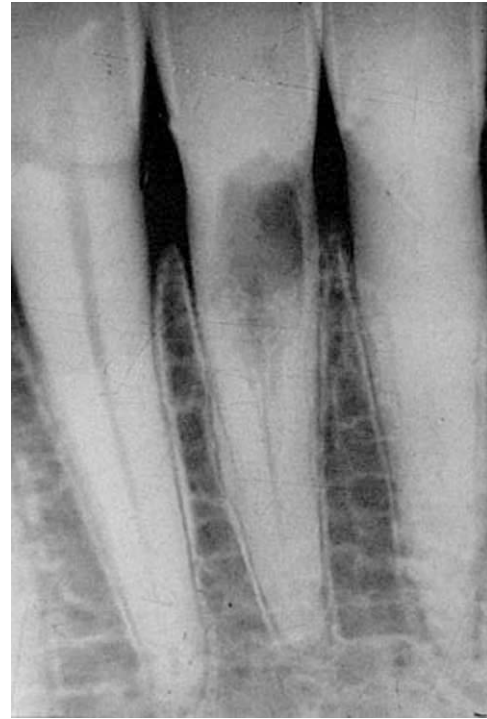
Radiograph showing the typical appearance of CRR: the lesion is located in the cervical area, at the level of the crestal bone.
